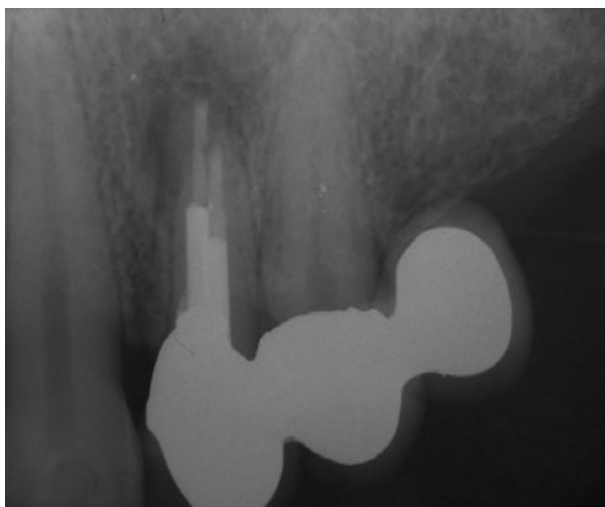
Healing of periapical lesion associated with tooth 14, 6 months after endodontic microsurgery.
